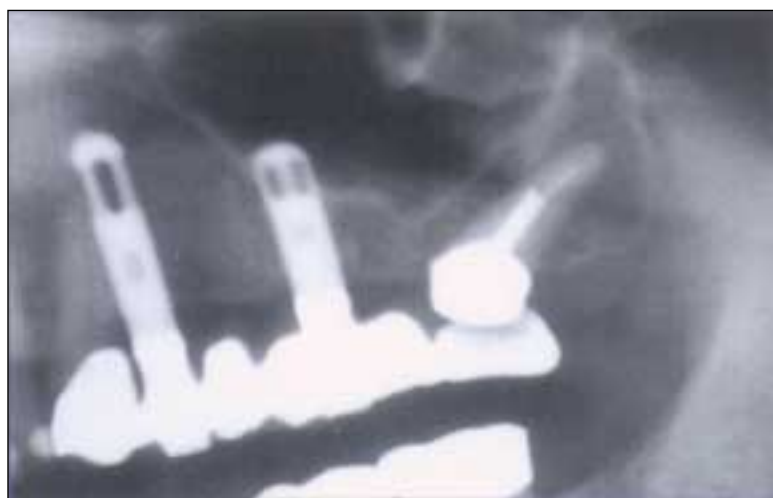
Panoramic radiograph showing the one incidence of tooth intrusion encountered in this study. Tooth intrusion occurred following 4 years of function.
